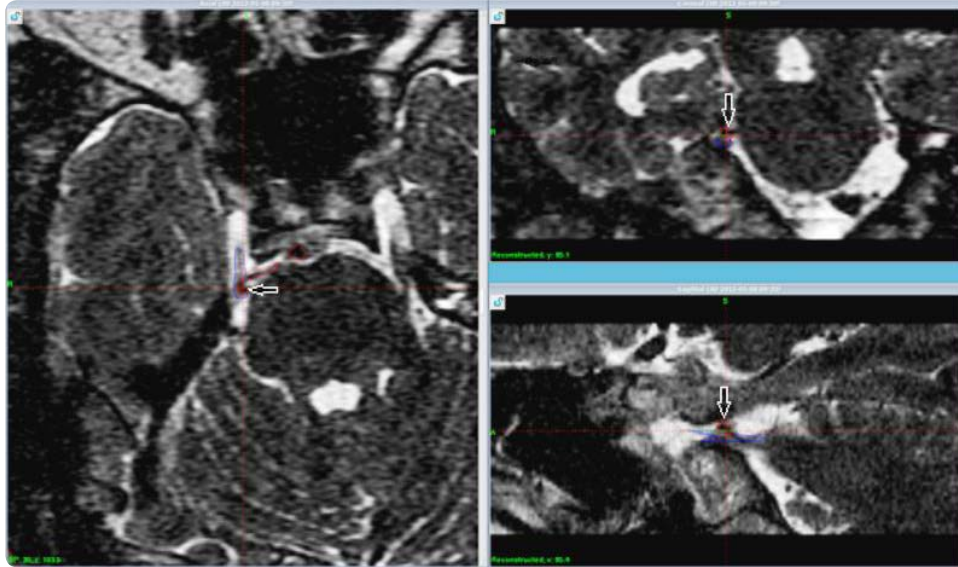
Axial 3D-T2 MRI with long TR value without contrast for 58 years old male patient with right side idiopathic trigeminal neuralgia treated with GKS to detected NVC complex displaying in gamma knife plan workstation showing the right trigeminal nerve as blue lined drawn structure and the detected blood vessel in contact (NVC complex) which is pointed to by white arrows in reconstruction Coronal and Sagittal images.
